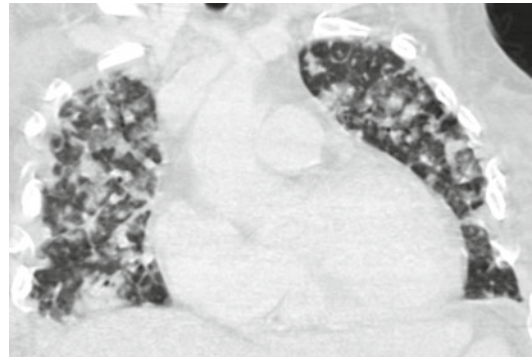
CT sagittal scan demonstrates multiple nodules in dependent portions of the lung
